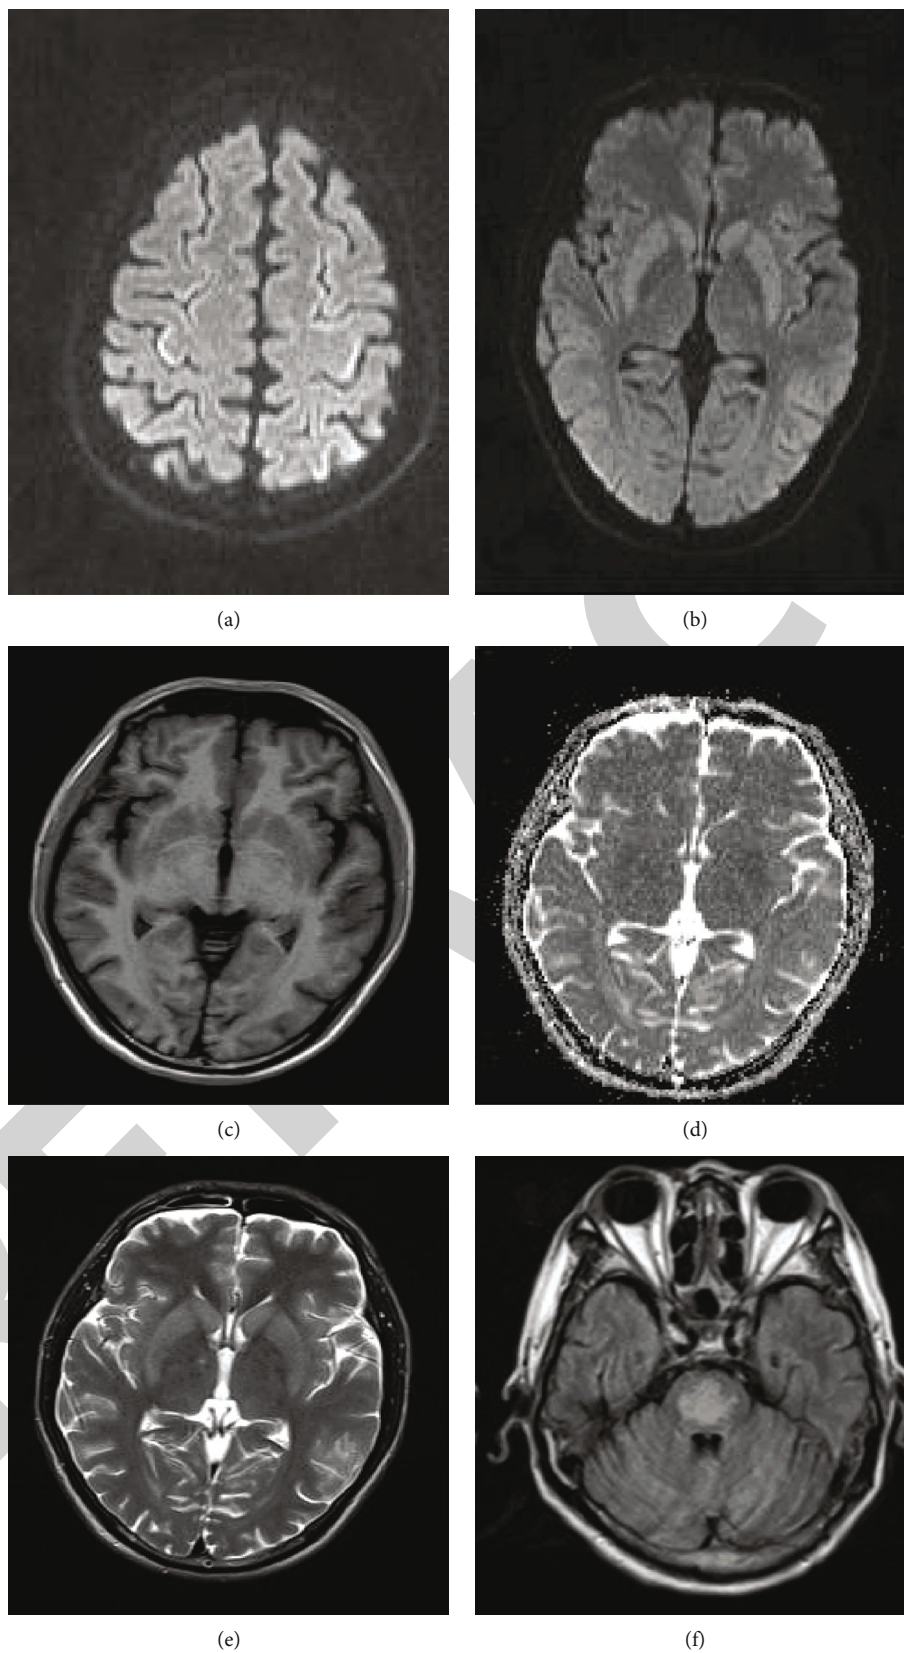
Extrapontine myelinolysis with central pontine myelinolysis: (a, b) axial diffusion-weighted images demonstrating restricted diffusion in the cerebral cortex and the basal ganglia; (c) T1 and (d) ADC map showing hypointensities in the basal ganglia; (e) T2 image demonstrating symmetric hyperintensities in the basal ganglia; (f) T2 FLAIR image demonstrating symmetric hyperintensities in the central pons.
